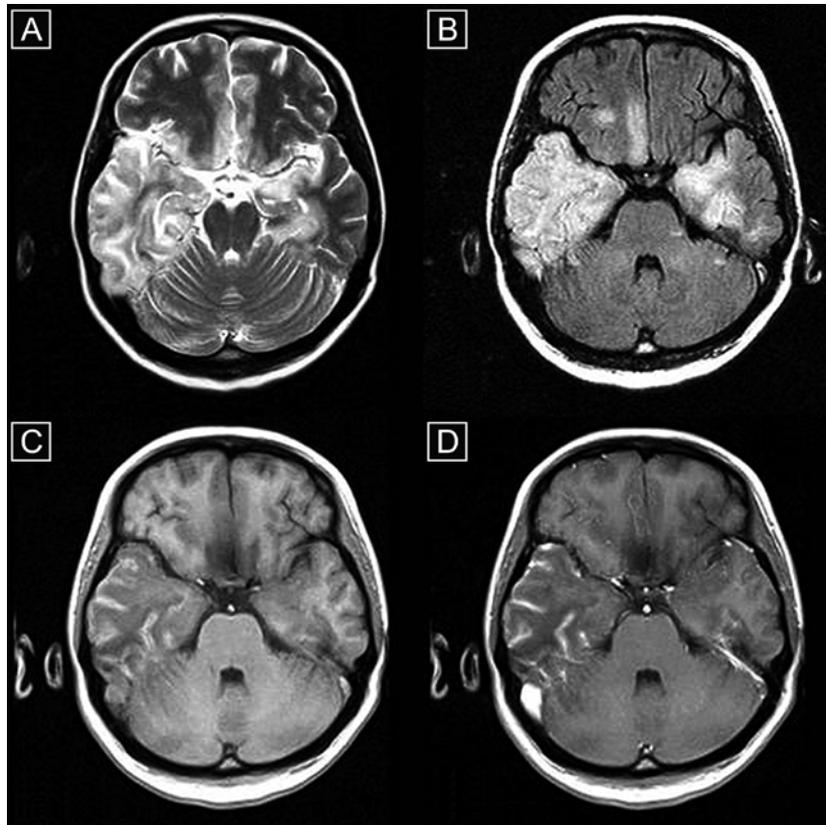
a-d. Bilateral, asymmetrical lesions in acute phase of HSE. On T2-weighted images (1.5T, TR/TE=5200/105) involvement medial parts of temporal lobes, more severe on the right side (a). The straight gyrus of the right frontal lobe involvement visible on FLAIR sequence (TR/TE=8000/120) (b). Cortical laminar necrosis of the right temporal lobe as linear hyperintense areas on T1-weighted images (TR/TE=585/15) (c), with band enhancement after contrast administration (d).
